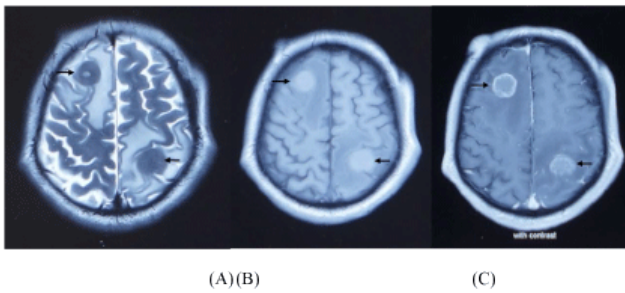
(A) Axial T2-weighted image reveals two heterogeneous intensity masses with peripheral high signal intensity consistent with oedema in the right frontal lobe and left parietal lobe. (B) Axial T1-weighted image. (C) Irregular rim enhancement can be seen after contrast material.
